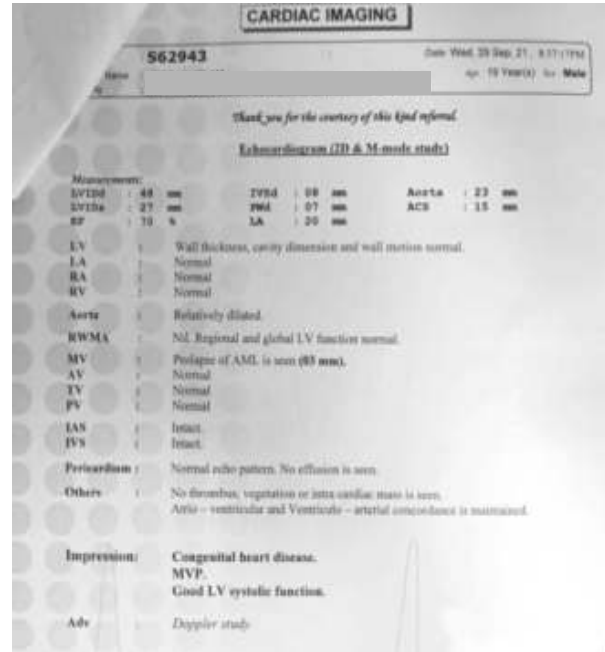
Echocardiogram report
